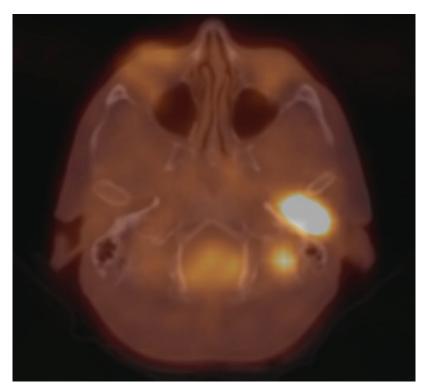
Axial positron emission tomography (PET/CT) view demonstrating increased uptake of radiotracer by the neoplasm.
